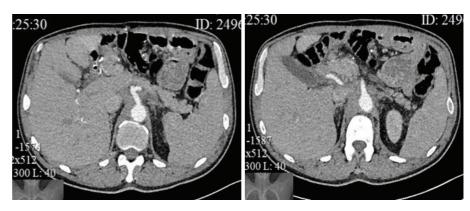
Abdominal CT scan. CT signs of soft tissue infiltration around the abdominal aorta
